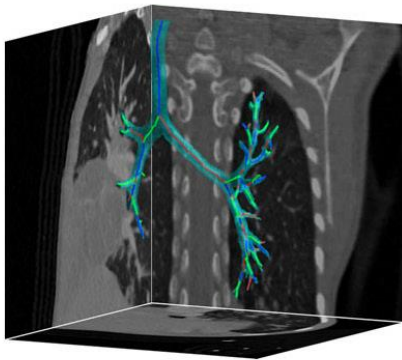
Airway centre line and bifurcation point detection from a paediatric chest CT scan
